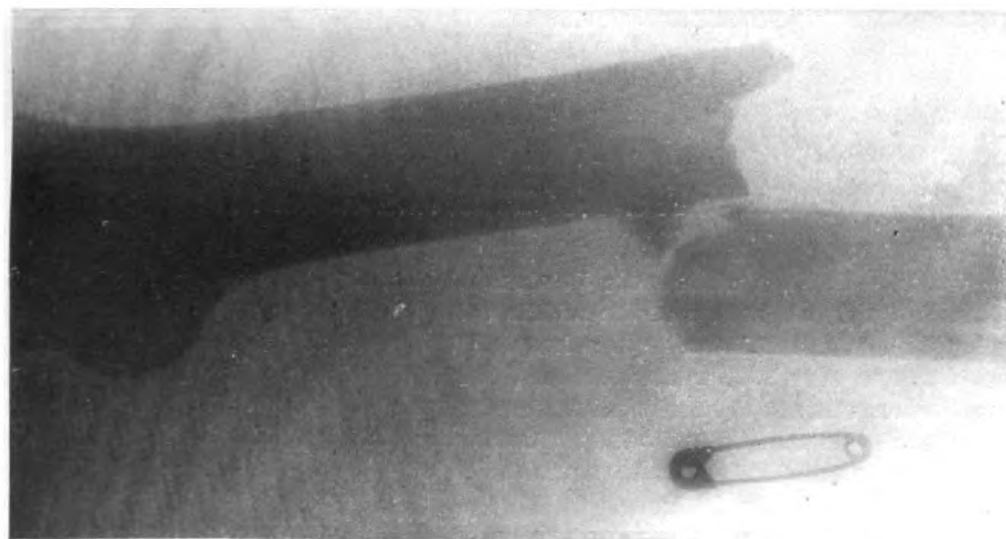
Case 5. Preoperative anterior-posterior x-ray.
